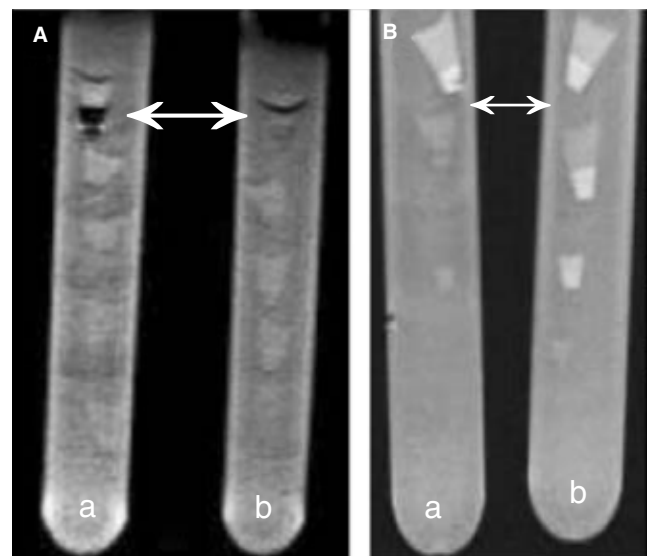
Representative MR images of cell pellets in test-tubes. Each pellet contains 5×10^6 D430B lymphoma cells and 5×10^6 Raji lymphoma cells on T2*-weighted images (A) and on T1-weighted images (B), with of USPIO-anti-CD20, respectively. A) D430B cells-USPIO-anti-CD20 showed an important decrease of SI on T2*-weighted images that is more evident in the pellet treated with 0.03 $\mu\text{mol Fe/l}$ of USPIO-anti-CD20, whereas Raji cells-USPIO-anti-CD20 showed a slight hypointensity in the same sequences (double arrow). B) D430B cells-USPIO-anti-CD20 showed a SI enhancement on T1-weighted images and Raji cells-USPIO-anti-CD20 an inhomogeneous hyperintensity on T1-weighted three-dimensional fast field echo images (double arrow).
